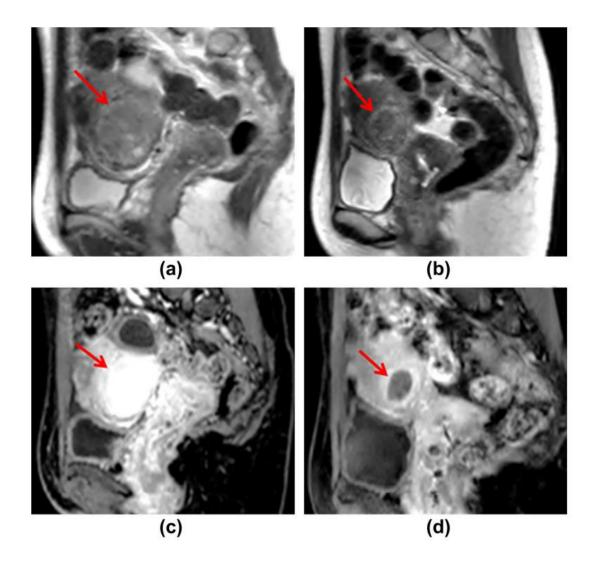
(a) Sagittal T2-weighted images showing an intramural fibroid with isointense/hyperintense signal compared to myometrium, which reduced by 77% nine months after the embolization (b, d). (c) Before UAE, the fibroid had also shown hyperintense signal compared to myometrium on contrast-enhanced T1-weighted images (Kalina et al, 2018).
